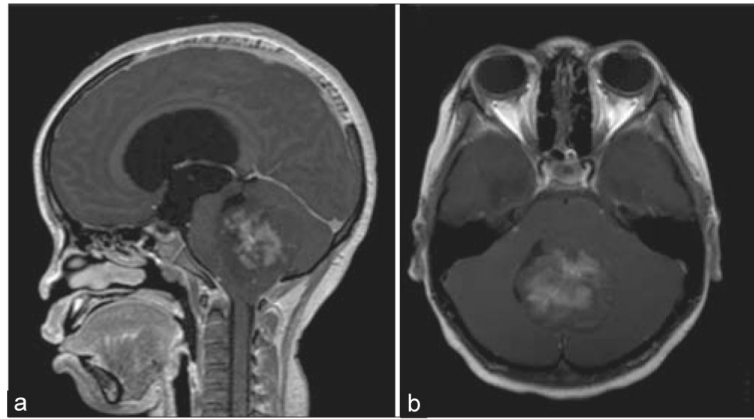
Radiographic characteristics of medulloblastoma. (a) Sagittal and (b) axial views of a T1-weighted magnetic resonance imaging after contrast administration demonstrating a heterogeneously enhancing mass located in the fourth ventricle
